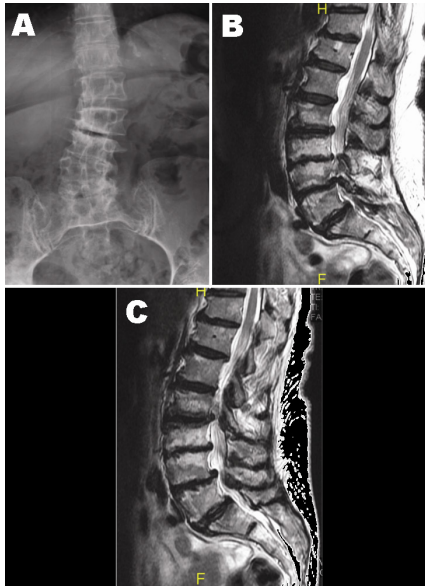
Pre operative anteroposterior X-Ray (A) and sagittal T2-weighted MRI scan (B, C).
